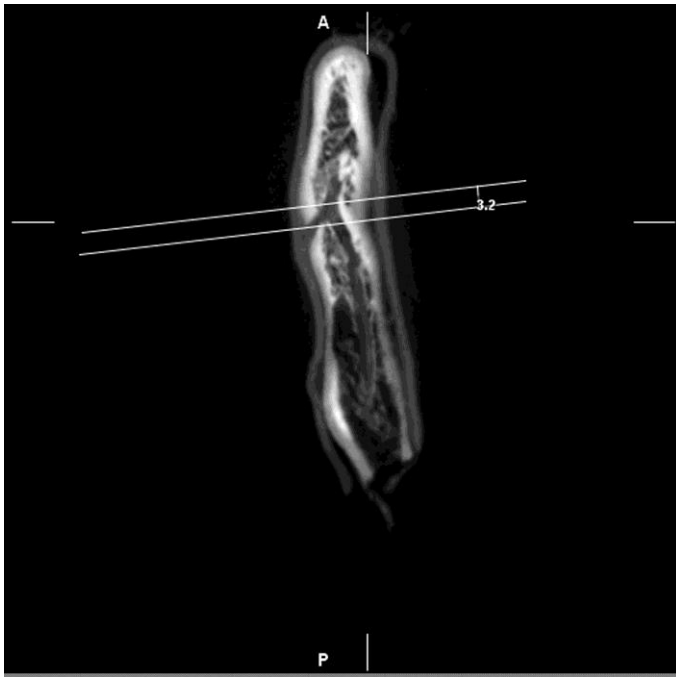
Measuring the distance between the most anterior point of the mental loop and the most mesial point of mental foramen in CBCT
